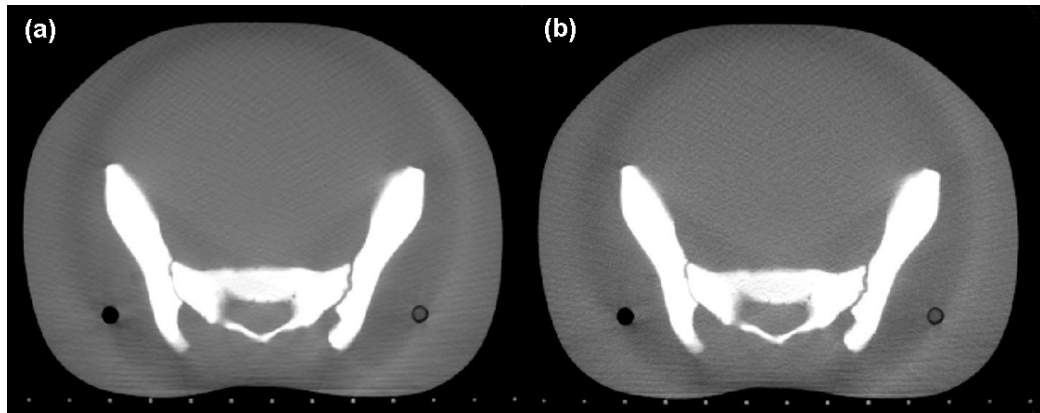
(a) standard dose mode (125 kVp, 80 mA, 25 msec) and (b) low dose mode (125 kVp, 40 mA, 10 msec) images from pelvic cone beam CT. Note that the image noise increases in lower dose techniques (b), however this does not affect the ability to localize the patient based on bony structures.
